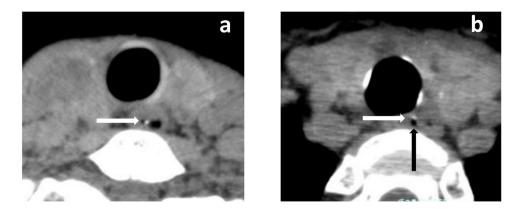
The 3-dimensional multidetector-computed tomography (MDCT) images, transverse planes. (a) Thyroid level shows oral side edge of fish bone existing in the esophagus cavity, (b) T1 vertebral level shows distal end of fish bone penetrating out of esophagus (white arrow) and free air in the upper mediastinum (pneumomediastinum; black arrow).
